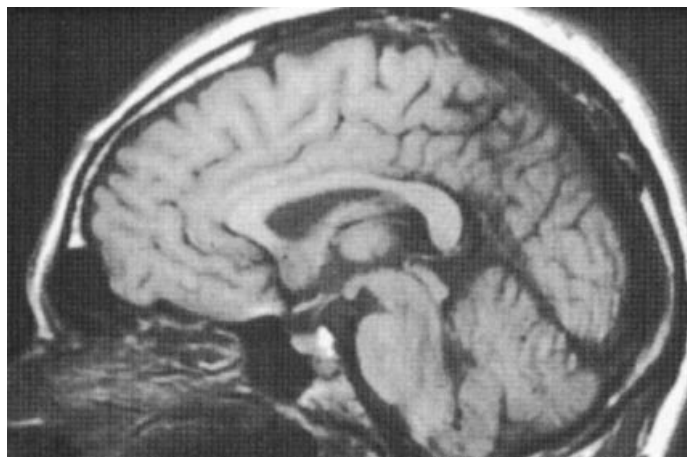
Sectional MRI image of a head.
